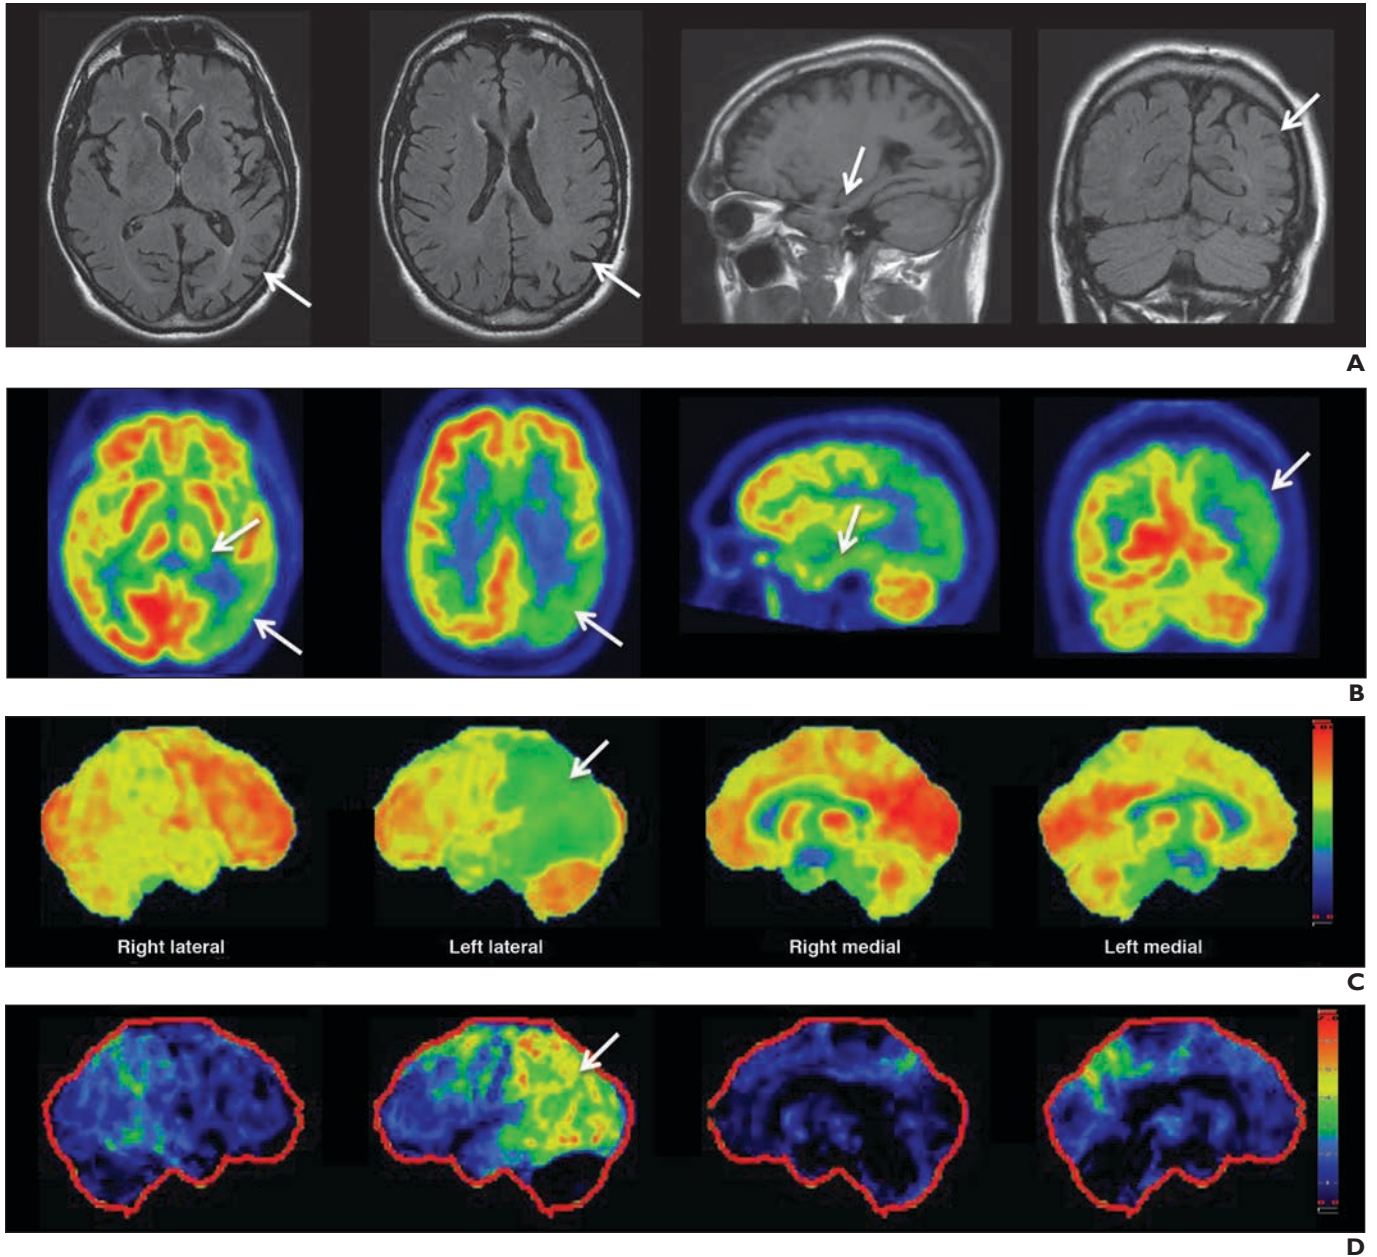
Corticobasal degeneration in 67-year-old man who presented with cognitive decline, expressive aphasia, right upper extremity rigidity, and focal myoclonus. A, Axial (*left image and middle left image*), sagittal (*middle right image*), and coronal (*right image*) T2-weighted FLAIR MR images show asymmetric cortical atrophy in left temporal and parietal lobes (*arrows*). B, Axial (*left image and middle left image*), sagittal (*middle right image*), and coronal (*right image*) FDG PET images reveal marked left temporoparietal hypometabolism with subtle decreased activity in left basal ganglia (*arrows*). C and D, Three-dimensional stereotactic surface projection (SSP) maps (C) and Z-score maps (D) confirm severe left-sided cortical hypometabolism (> 5 SD; *arrows*). Three-dimensional SSP images are semiquantitative sampling of metabolism from various cortical locations. Z-score images compare cortical metabolism with age-matched normative database; color change is based on reduction in metabolism relative to number of SDs from mean. For further explanation, see text.
